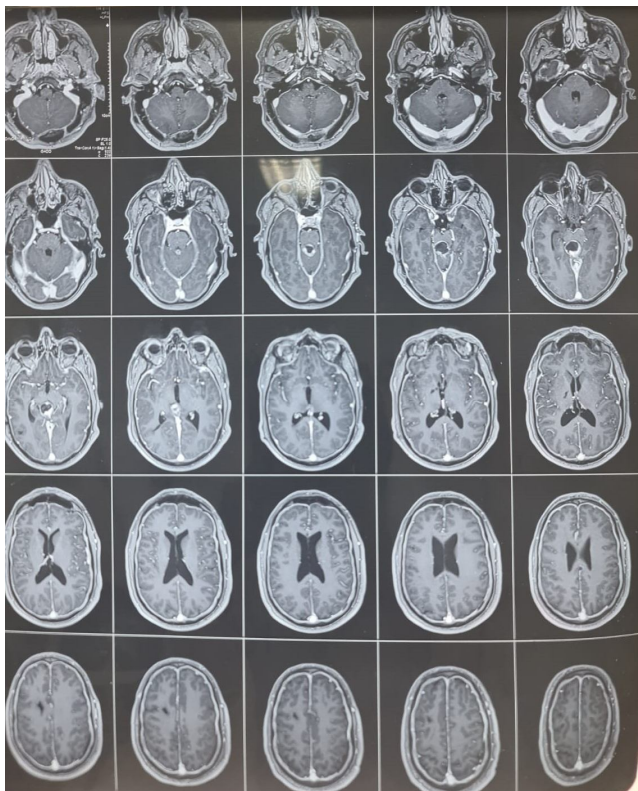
Axial T1-enhanced brain MRI, performed postoperatively, showing a small residue of the epidermoid cyst in the pineal region.
